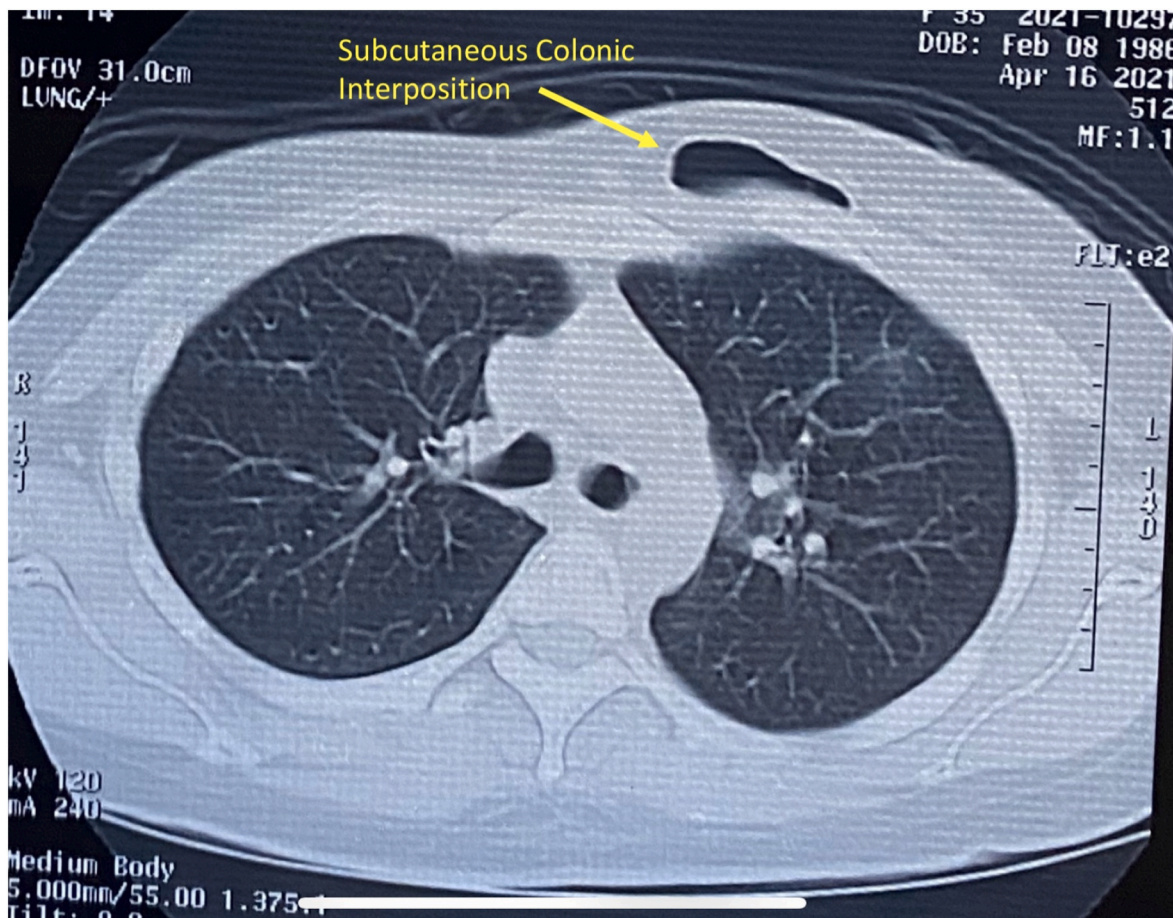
Contrast enhanced Chest computed tomography (CECT) on patient's 10th year follow-up. Subcutaneous colonic interposition (arrow) showed normal gas pattern with no signs of obstruction. Absence of suspicious mass at residual esophagus and stomach.
